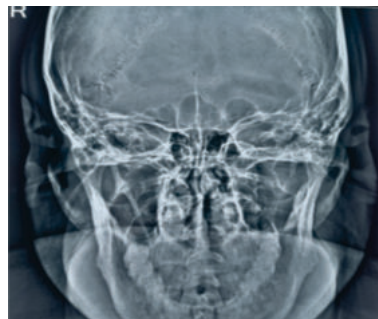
X-ray styloid complex PA view showing an elongated right styloid process.
